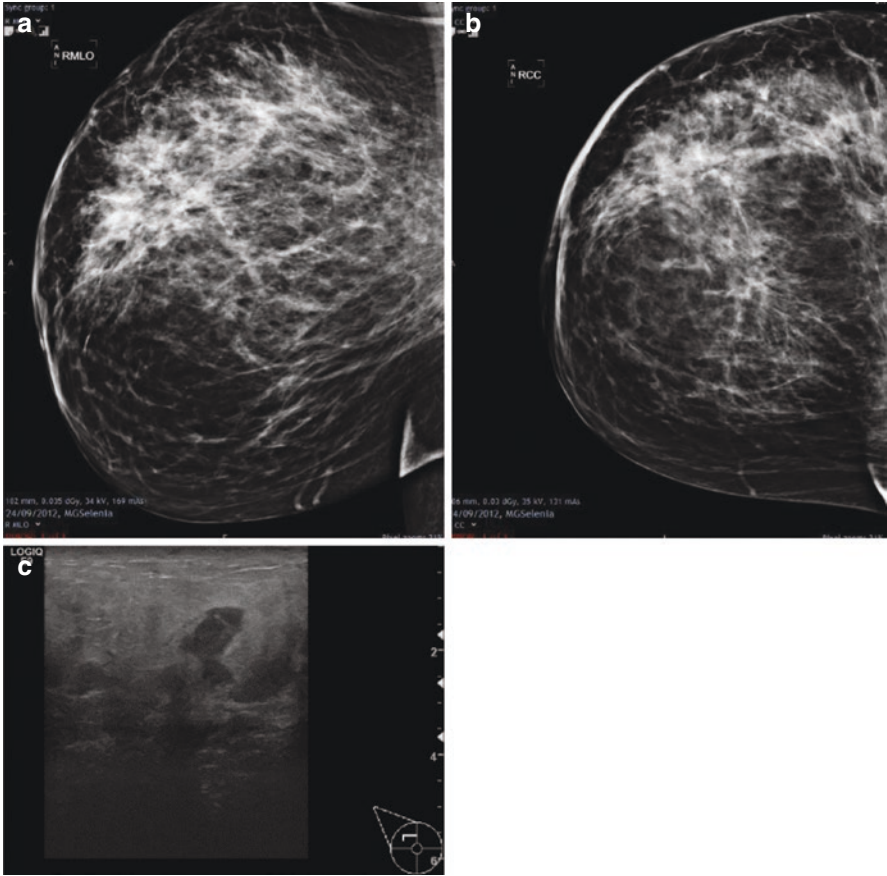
(a, b) A 38-year-old woman presented with diffusely tense, red, and swollen right breast. Mammograms show diffuse thickening of the dermis associated with increased trabecular pattern and asymmetrical density in the superior and lateral aspect of the right breast. (c) Ultrasound shows right upper outer quadrant diffuse edema of the dermis and intramammary fat associated with thickening of Cooper's ligaments associated with multiple hypoechoic lesions. Core biopsy confirms granulomatous mastitis. (d, e) Mammograms later show normal right breast
